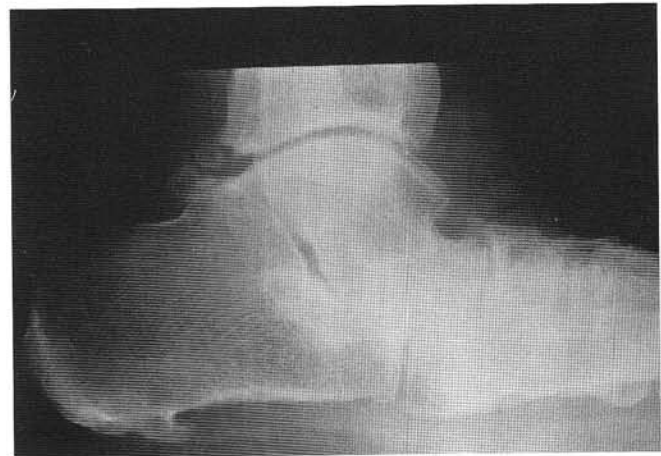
Lateral x-ray of a patient with advanced arthritis in the subtalar and midtarsal joints from long-standing TP dysfunction.
